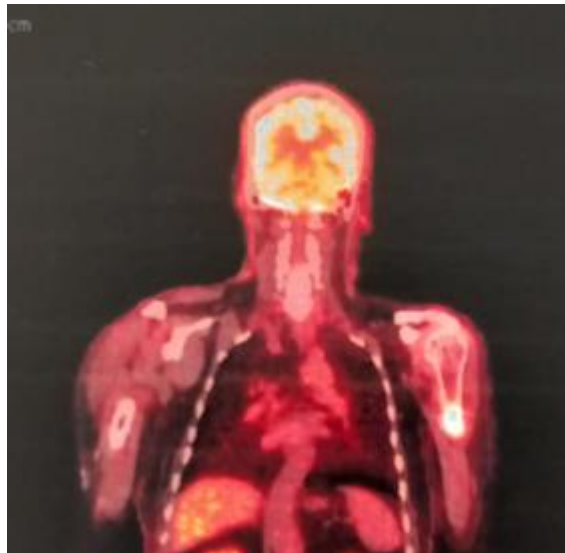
PET/CT demonstrating intense hypermetabolism of the proximal left humeral lesion, associated with pulmonary micronodules and mild hypermetabolism in the right thyroid lobe
